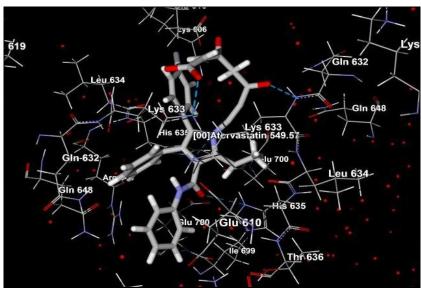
DOCKED VIEW OF [00] ATORVASTATIN USING LIGAND ENERGY INSPECTOR
